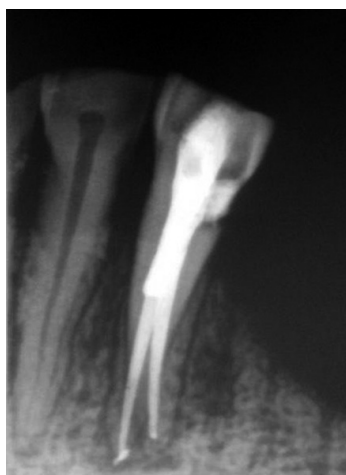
Post Obturation Radiograph 33
